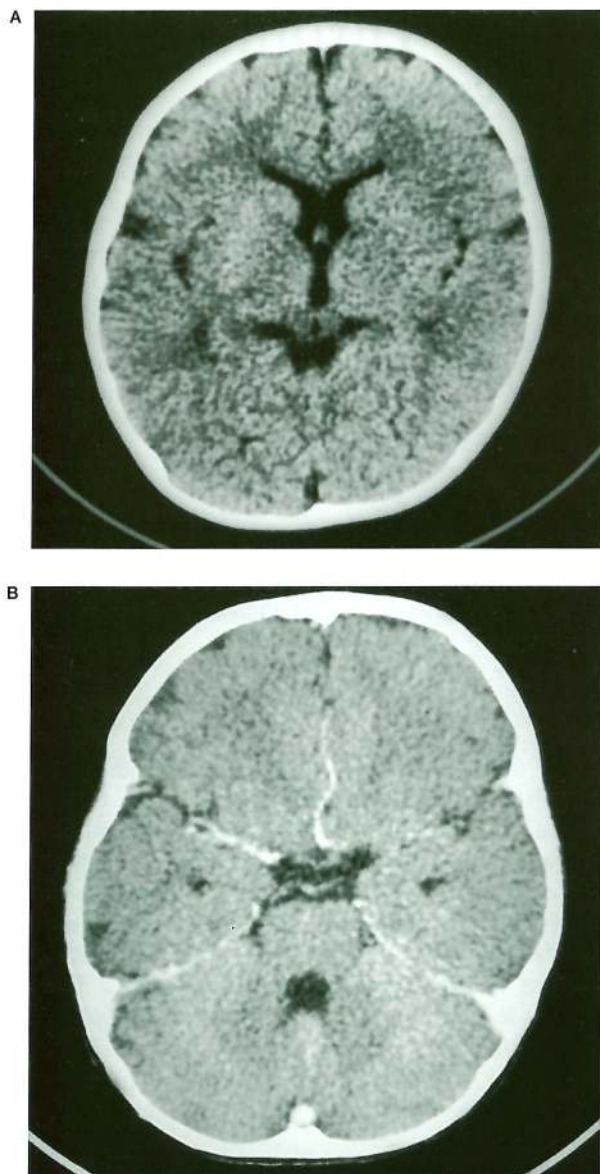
A) Computed tomographic scan, obtained within 2 hours of onset, failing to demonstrate early signs of acute infarction. B) Contrast-enhanced computed tomographic scan, obtained within 2 hours of onset, disclosing absence of left middle cerebral artery opacification.
